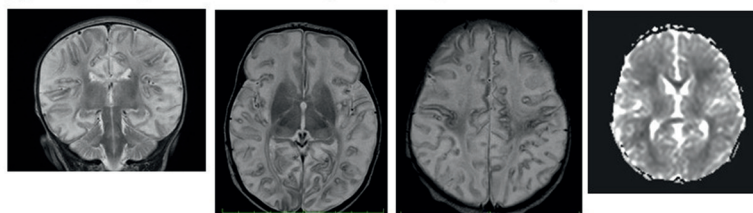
MRI and MRS images from two participants with (A) Favourable outcome, and (B) Adverse outcome
